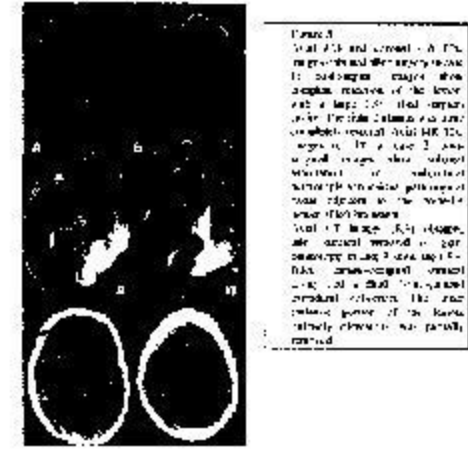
MRI scans showing cross-sections of the brain with heterotopia.
